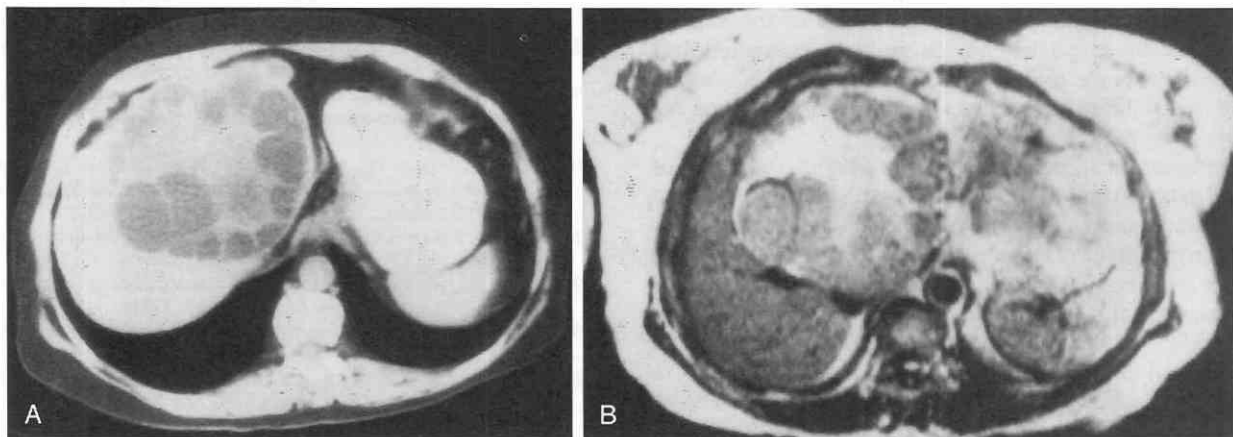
Echinococcal cyst. *A*, Contrast-enhanced CT scan shows a large cyst in the liver that contains multiple daughter cysts, which indicate viability. *B*, T2-weighted image demonstrates the low-signal-intensity rim that corresponds to the collagen-rich pericyst. The daughter cysts are slightly hyperintense relative to the liver but hypointense relative to the very high signal intensity of the internal hydatid fluid.
